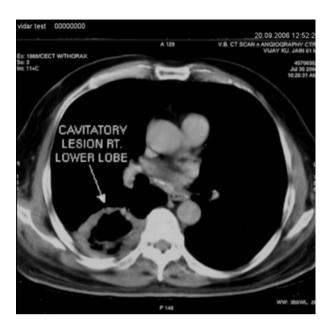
CT scan of the lesion showing a thick-walled cavity in the right lower lobe.
